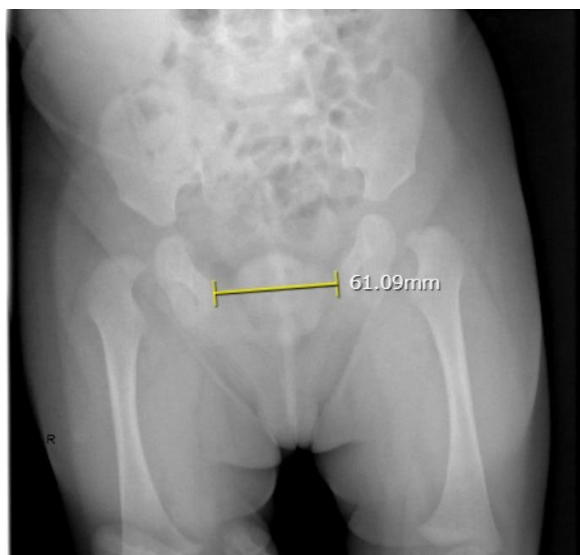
Pelvic X-ray (anteroposterior view)
